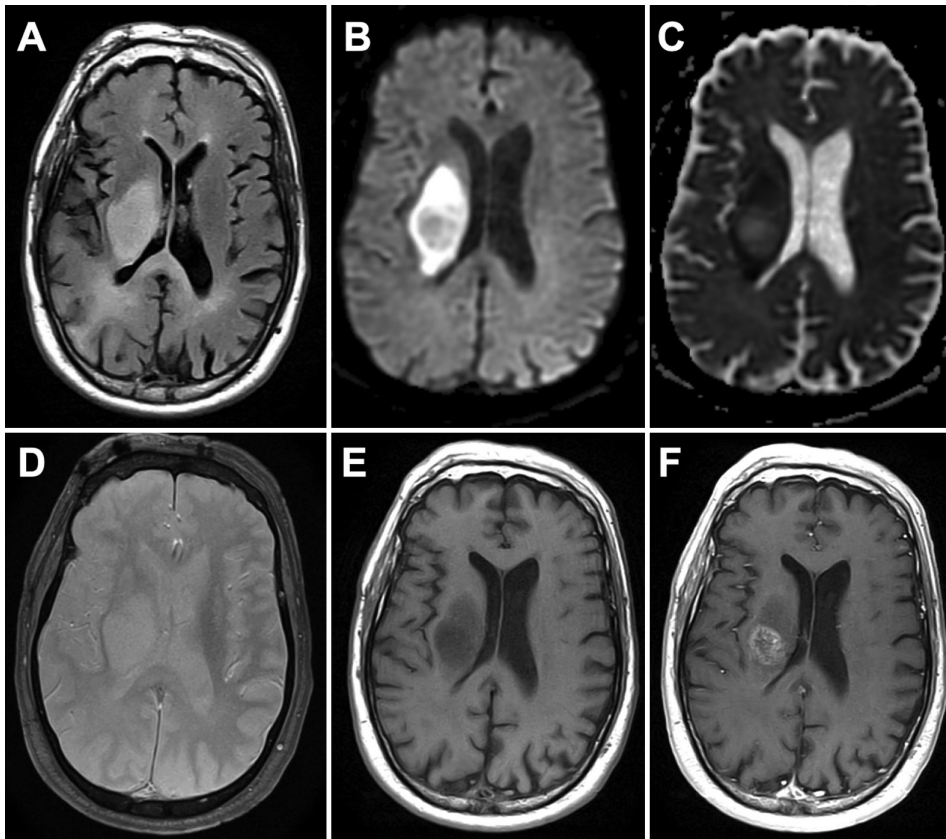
Two-month follow-up MR images of the brain demonstrating lesion growth and new contrast enhancement. T2-FLAIR (A), diffusion-weighted (B), ADC (C), and susceptibility-weighted (D) sequences demonstrating a right basal ganglia lesion, now with increased signal heterogeneity and size as well as persistent peripheral diffusion restriction. There is also new ring-like contrast enhancement in the center of the lesion, as shown by T1 pre- (E) and post-contrast (F) sequences.
